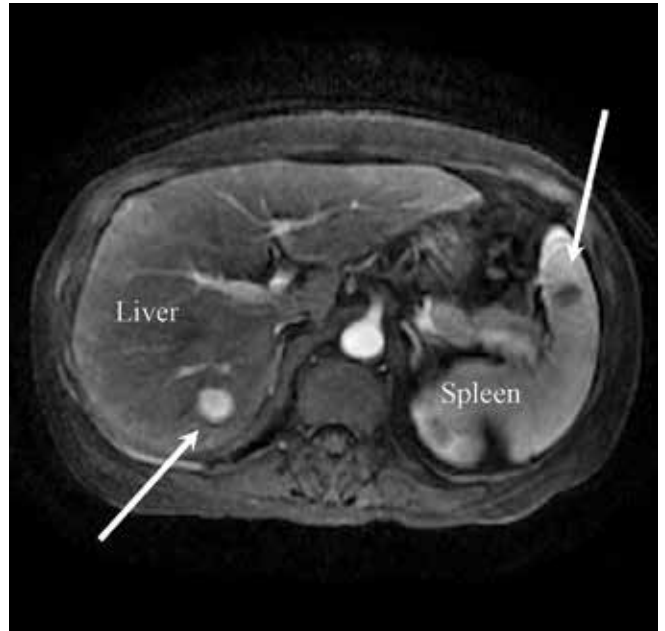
Magnetic resonance imaging of the abdomen reveals a 1.7-cm lesion in hepatic segment 6 (left arrow) and a 1.6-cm hypoenhancing lesion within the inferior pole of the spleen (right arrow).
